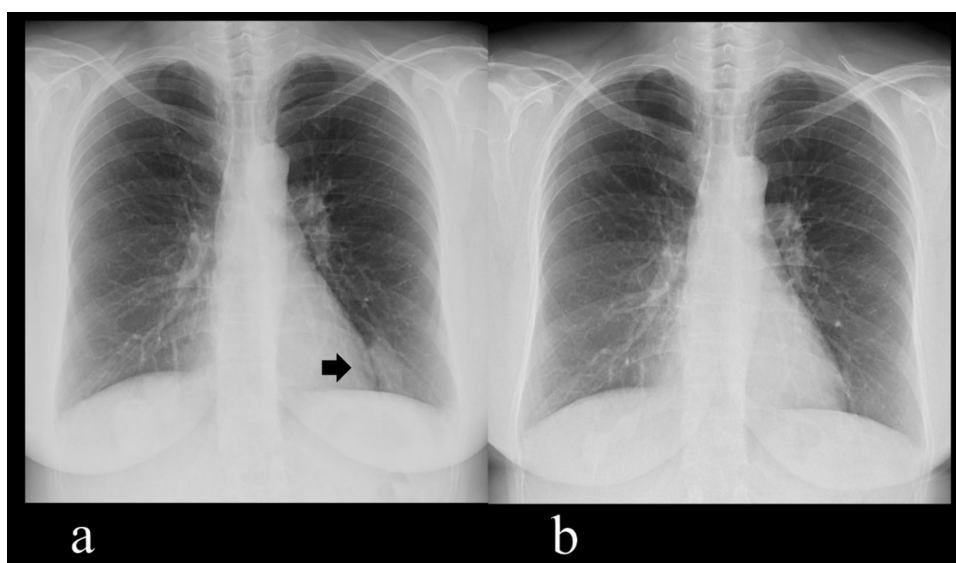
Changes in chest X-rays of Patient 1. (a) Nodule at the time of the diagnosis of lymphoproliferative disorder (LPD) (arrow). (b) The nodule disappeared 4 months after discontinuation of methotrexate (MTX).
